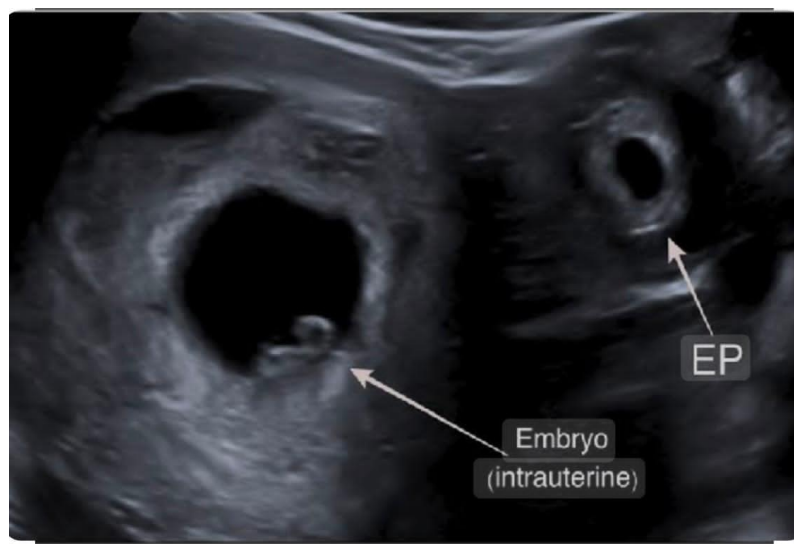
Follow-up ultrasound confirming heterotopic pregnancy at 9 weeks of pregnancy.
